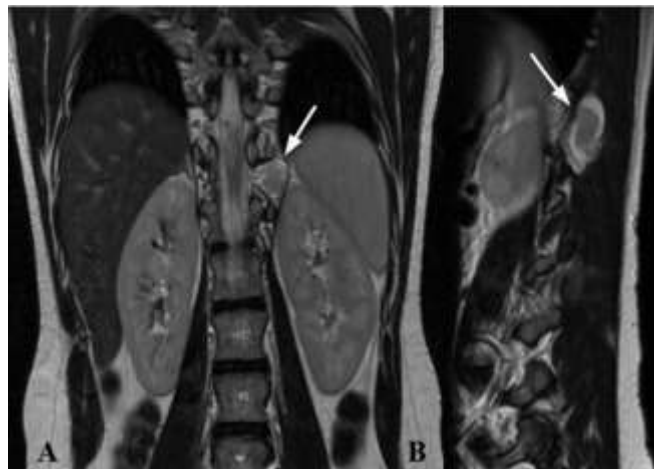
MRI of a 16 years old patient with NF2. Coronal T2w (A) and sagittal T2w (B) show at D11 level on the left posterior parame-dian and median region a well-defined lesion (white arrow) with heterogeneous signal on T2w images with peripheral areas of hyperintensity, which indicates cystic or myxoid degeneration.
